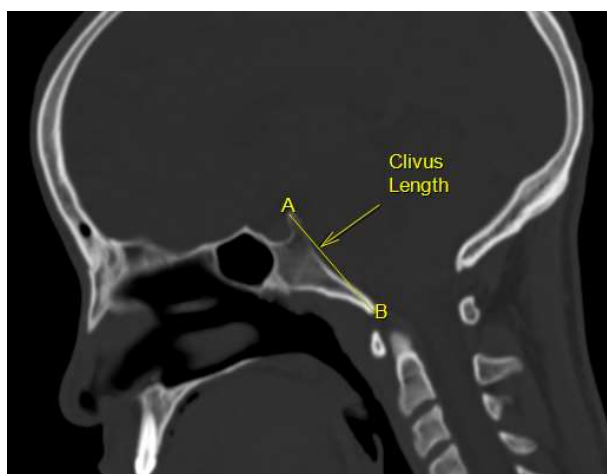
Measurement of the clivus length on a sagittal cranial CT scan from A to B, where A = upper tip of the dorsum sellae, and B = basion (unit of measurement: centimeters).
